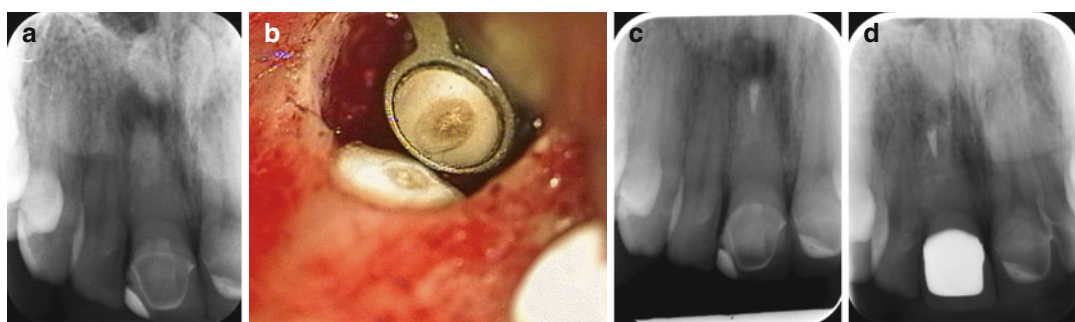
Successful outcome of a surgical root canal treatment of a right central incisor with a root canal obliteration and apical periodontitis after trauma. (a) Preoperative radiograph, (b) the tip of the root-resected central incisor
